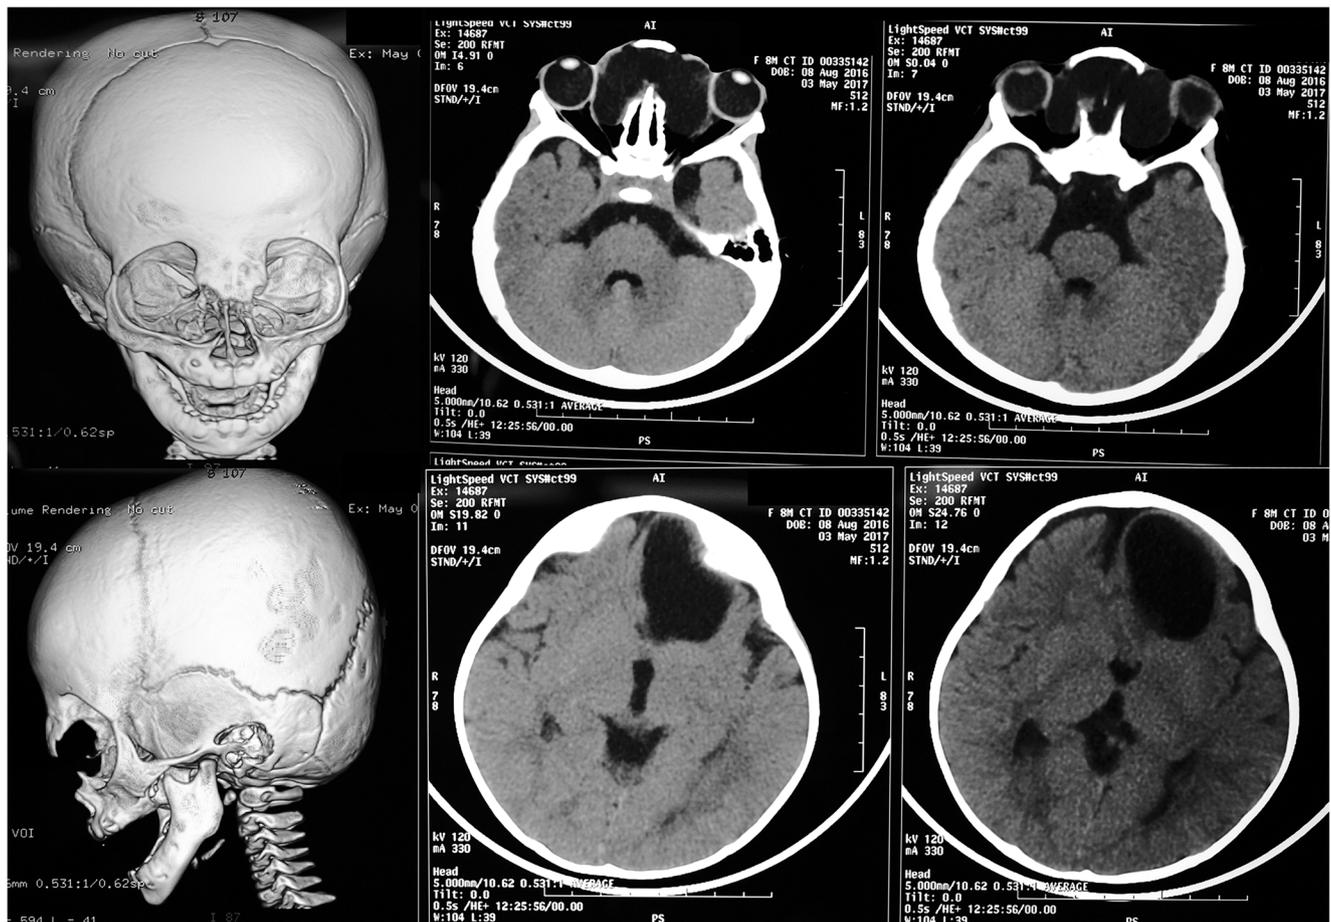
Pre-operative CT scan with 3D reconstruction: external bony defect in NE and NO (*upper and lower left*) and CSF-containing sac in NE-NO encephaloceles (*middle and right*)
